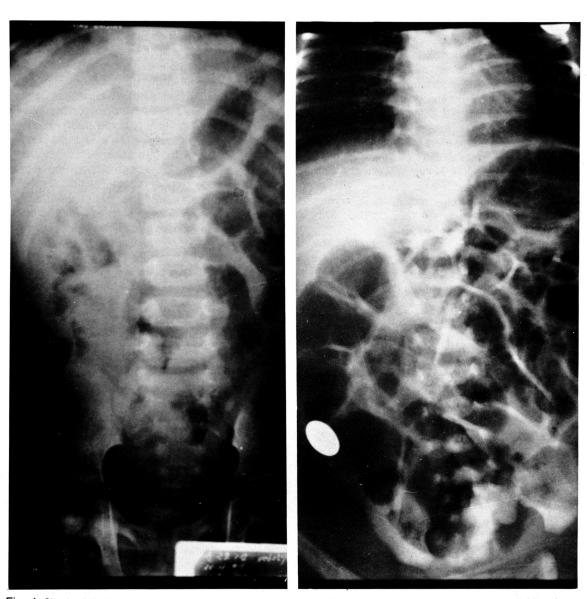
Simple abdominal X-rays of patient 1 (left) and patient 2 (right). Note marked dilation of bowel loops with fluid and gas.
